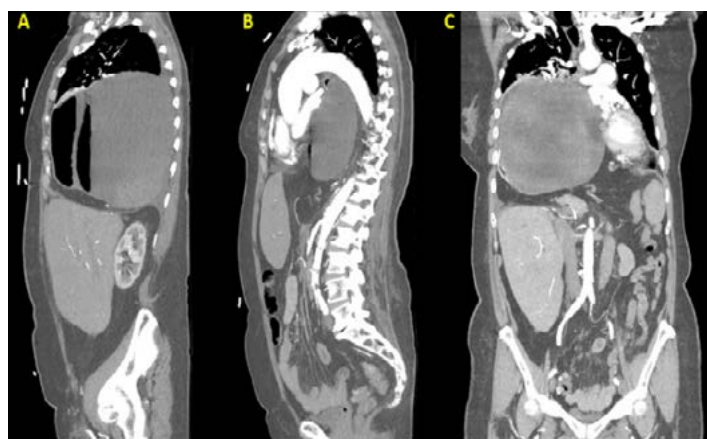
Computed tomography showing (A) large gastric volvulus in the right hemithorax (sagittal view) causing compression and displacement of the cardiac structures (B) anteriorly (sagittal view) and (C) to the left (coronal view).
